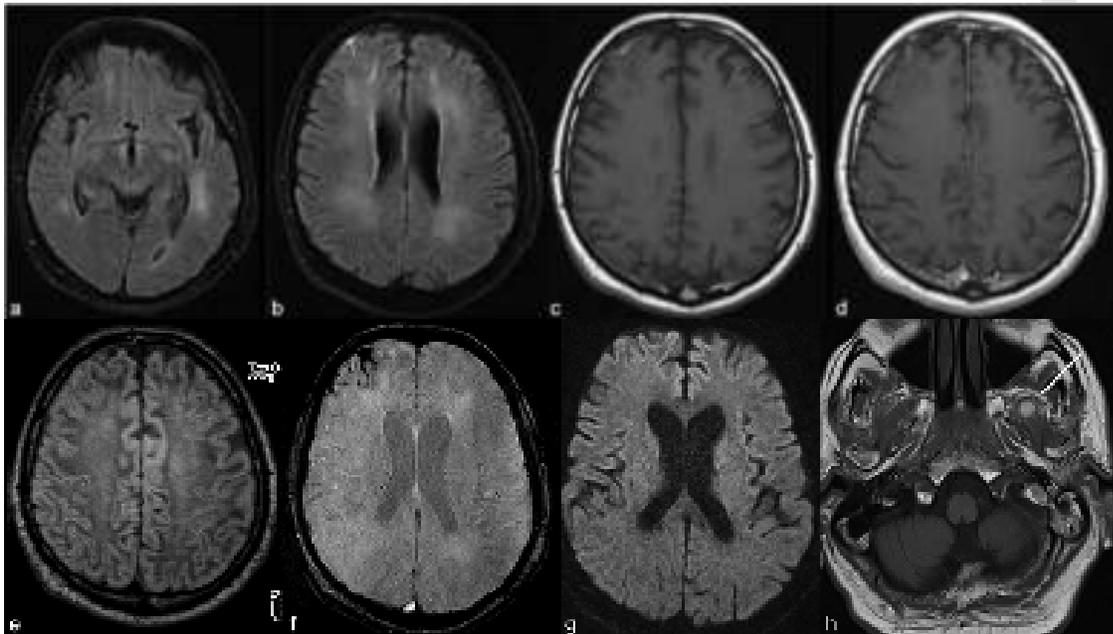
Control MRI of the 1st patient after 6 days. Axial FLAIR images at level of midbrain (a) and centrum semiovale (b) show interval regression of the white matter hyperintensities. Axial T1WI (c) shows persistence of sulcal effacement and a new focus of right frontal subacute hemorrhage. On post-contrast T1WI (d), there is still mild cortical enhancement, but post-contrast FLAIR (e) image shows complete resolution of pial-subarachnoid enhancements. Axial SWI (f) clearly depicts interval progression of blooming in the right frontal lobe. Axial DWI (g) demonstrates only mild parafalcine frontal cortical diffusion restrictions. As an ancillary new finding in the follow-up MRI, a round hyperintense mass compatible with subacute hemorrhage is seen in the left lateral pterygoid muscle (arrow) on axial T1WI (h) at the level of skull base.
